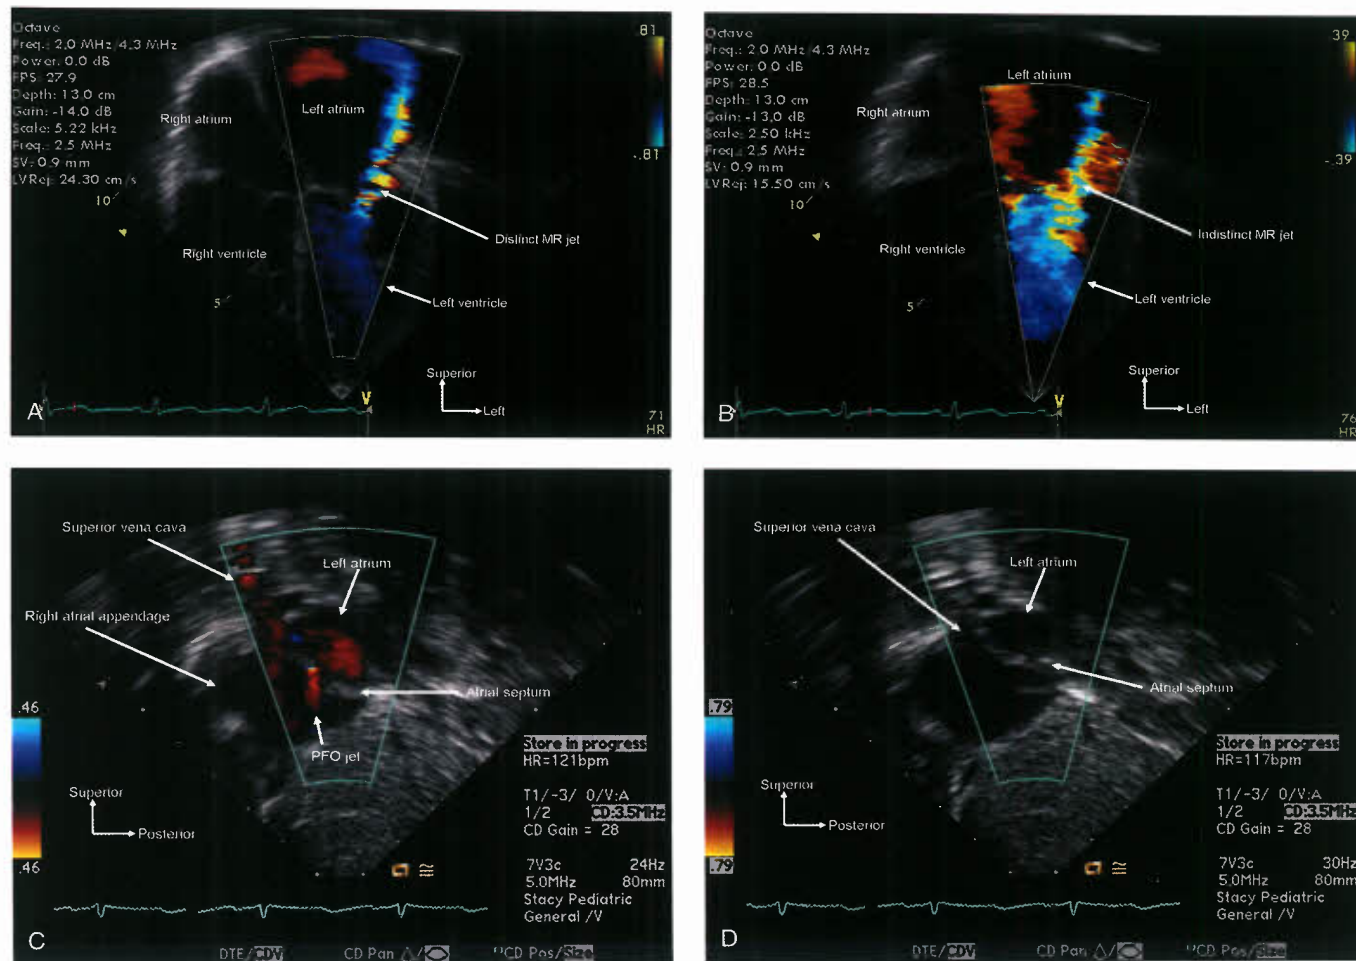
Series of four images demonstrating inappropriate and appropriate color aliasing limits during the echocardiographic examination. Throughout an echocardiographic examination the echocardiographer must actively decrease and increase the color aliasing limit depending on the expected velocity of the color jet being interrogated. For example, in evaluating high-velocity jets such as mitral insufficiency, color aliasing limits should be high as in this apical four-chamber view shown in (A) where the velocity limit is 81 cm/s. This provides a clean, crisp, and interpretable display of the mitral insufficiency flow. Inappropriate low color aliasing limit as in (B) (39 cm/s) produces an indistinct display of the mitral insufficiency jet. On the other hand, when evaluating a low-velocity color jet such as a patent foramen ovale (PFO) the color aliasing velocity should be lower to enhance recognition and display as in the subcostal image (C) where the aliasing velocity is 46 cm/s. If the aliasing velocity is set too high (79 cm/s in this example), detection of the low-velocity PFO jet may be impossible (D).
